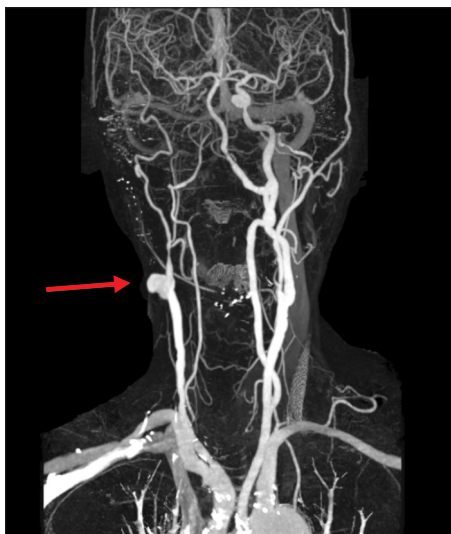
Computed tomography angiography showed a pseudoaneurysm (arrow) at the right carotid bifurcation connecting to the skin, occluded internal carotid artery, and severely stenotic external carotid artery.
